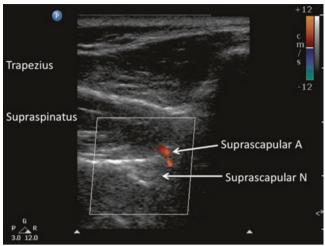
Ultrasonographic image of the suprascapular nerve on the floor of the scapular spine between suprascapular notch and spinoglenoid notch. Both suprascapular nerve and artery run underneath the fascia of supraspinatus muscle. (Reproduced with permission from Philip Peng Educational Series)
